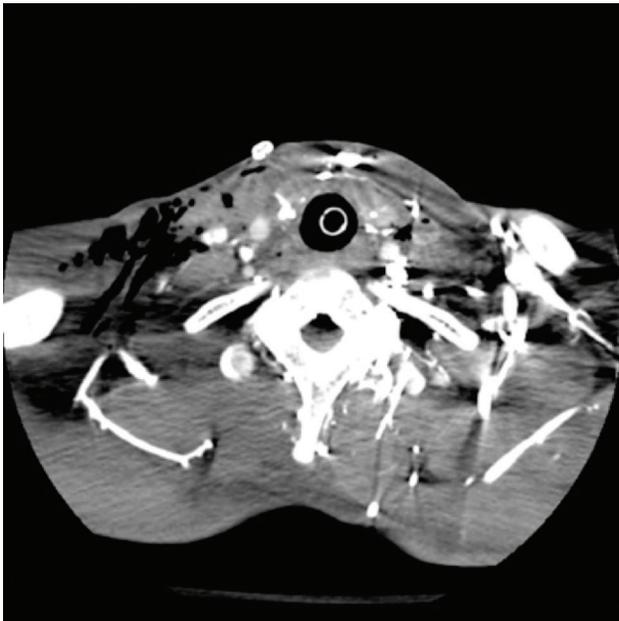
Axial contrasted CT (computed tomography) scan of the neck following penetrating neck trauma revealing significant and diffuse subcutaneous emphysema. The patient had undergone a limited neck exploration at a Role 2 facility without significant findings, but endoscopic assessment of the upper aerodigestive tract was required to complete the evaluation. There was some ecchymosis without laceration or perforation of the pharyngeal wall noted.
